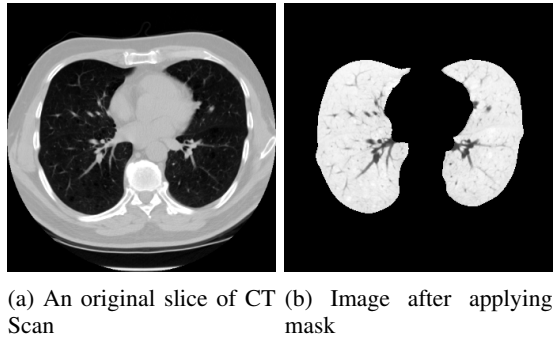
Application of mask on lung CT Scan
